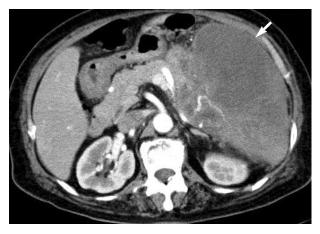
Abdominal computed tomography reveals a large heterogenous hypodense neoplasm in the distal pancreas and spleen (arrow).
